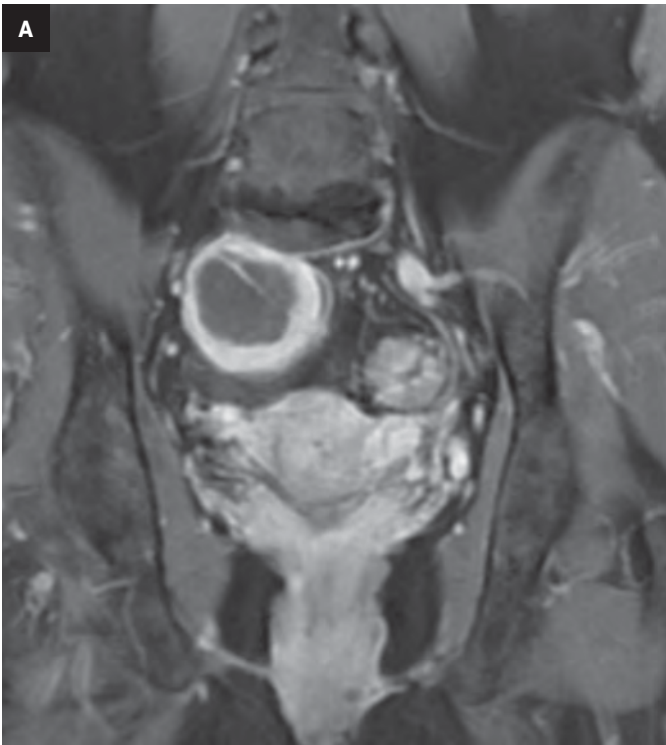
Coronal (A) and sagittal (B) postcontrast T1 MRI of the pelvis demonstrate a thick-walled rim enhanced cystic mass with central necrosis in the right hemipelvis and associated with mild regional mass effect on the posterior aspect of the uterus.
